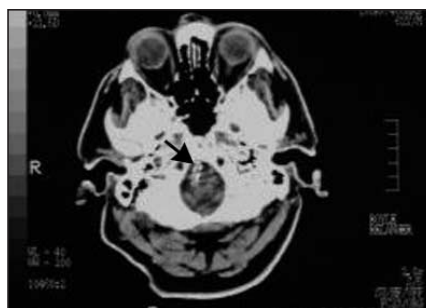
CT of the head, showing calcification of the right vertebral artery (black arrow).
